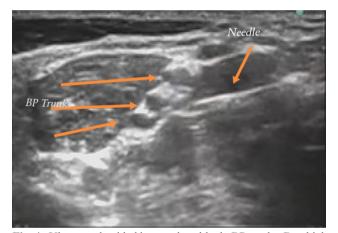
Ultrasound guided interscalene block; BP trunks: Brachial plexus trunks.
